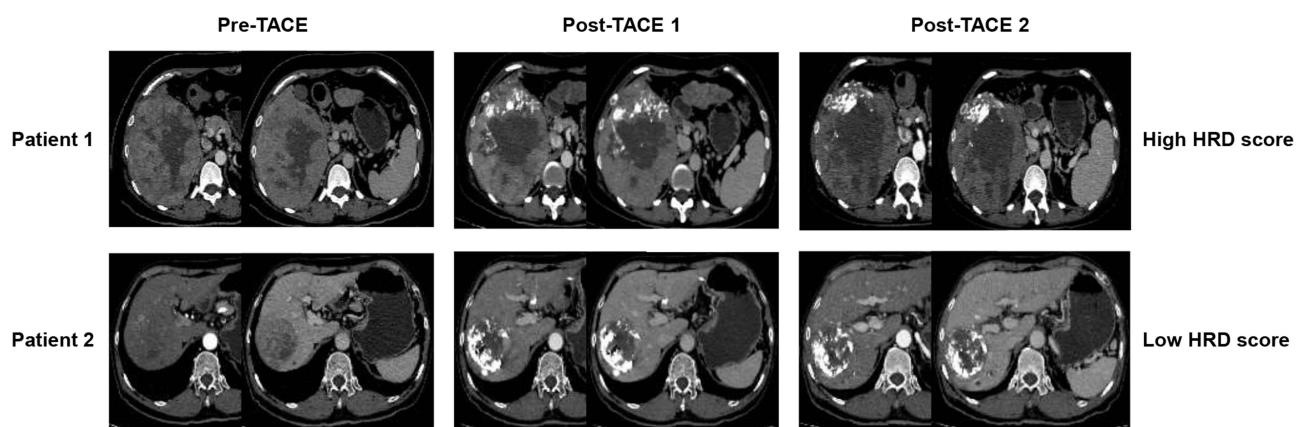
CT images of two patients before transarterial chemoembolization, after initial treatment, and after re-treatment, respectively. From the CT images (both arterial phase and venous phase), it can be seen that patient 1 with a high HRD score had a larger tumor with significant internal necrosis, less iodine oil deposition after both initial and repeated TACE and no significant reduction in the volume of the living tumor; patient 2 with a low HRD score had a smaller tumor, with a gradual increase in iodine oil deposition and a reduction in the volume of the living tumor after two consecutive TACE sessions.
